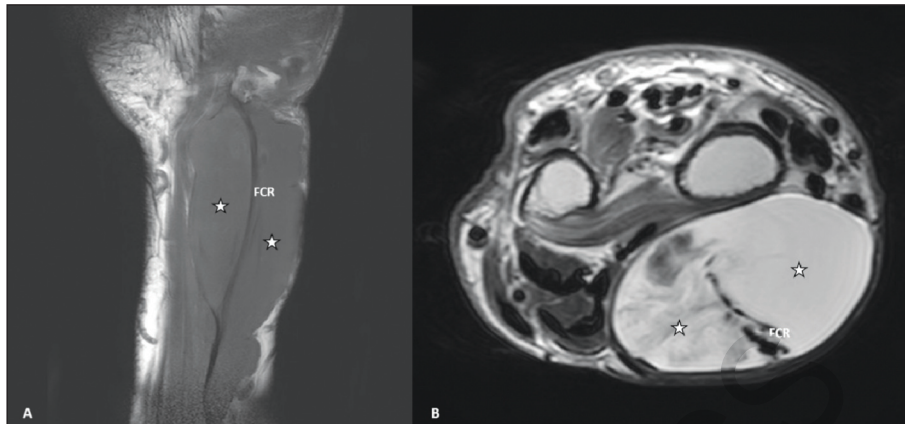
Hypertrophic tenosynovitis of the FCR in magnetic resonance imaging. A (coronal T1 image), B (axial T2 image) synovial pannus (stars). FCR: Flexor carpi radialis.
